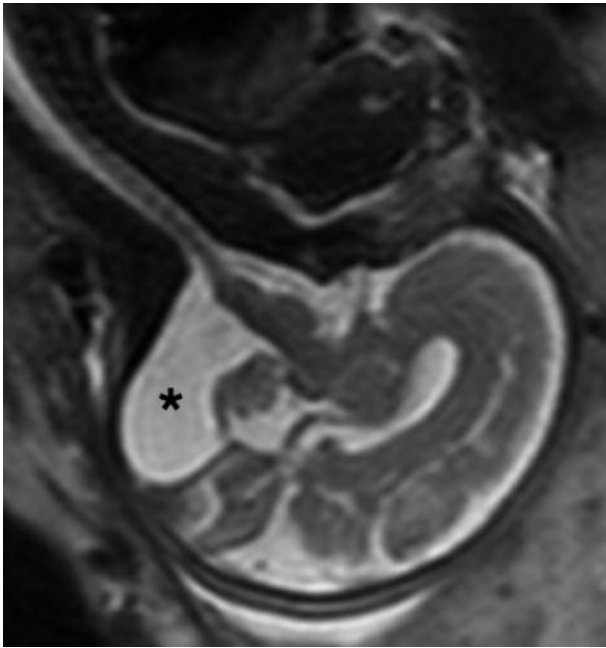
MRI midsagittal view of a Dandy-Walker malformation, showing an enlarged retrocerebellar space (*), cerebellar hypoplasia and upward displacement of the tentorium.
